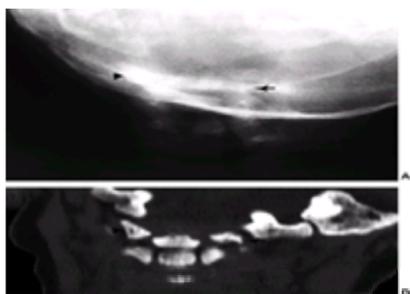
This 2-month-old girl presented with left-sided torticollis. Physical examination revealed no tightness in the sternocleidomastoid muscle, but reduced right lateral extension was present. A: An anteroposterior radiograph of the cervical spine demonstrates the head tilt and suggests a hypoplastic lateral mass on the patient's left at C1 (arrow) compared with that on the patient's right (arrowhead). B: A computed tomography scan with frontal reconstruction clearly demonstrates the left hypoplastic lateral mass of C1 (arrow), with a normal right lateral mass (arrowhead). Further workup of this child demonstrated nearly complete tracheal stenosis, which required reconstructive surgery. The lateral tilt of the neck has been slowly resolving with gentle physiotherapy and improvement of normal cervical muscle motor tone.
